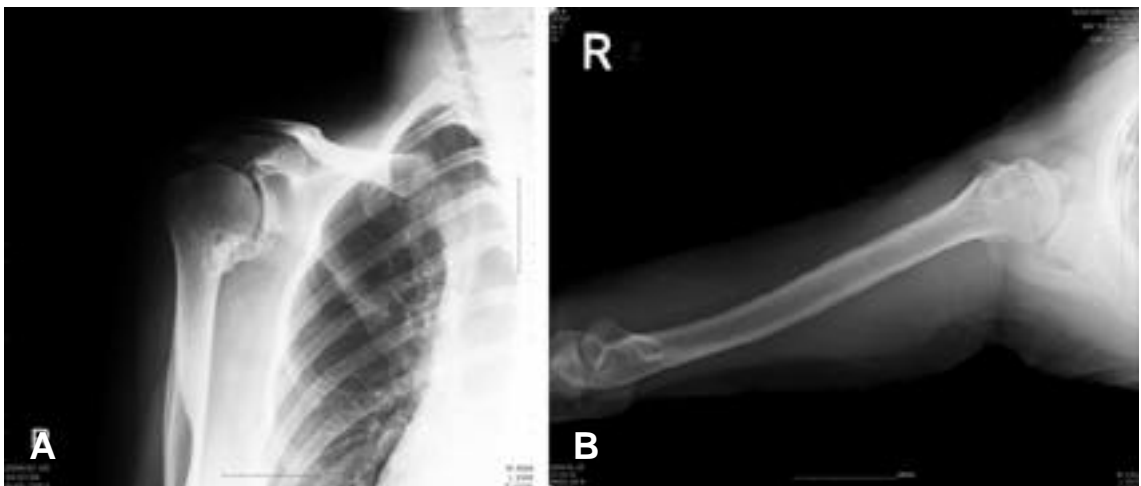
Plain X-rays of the right shoulder showing the extent of the heterotopic ossification between the proximal humerus and at the vicinity of the coracoid process.
